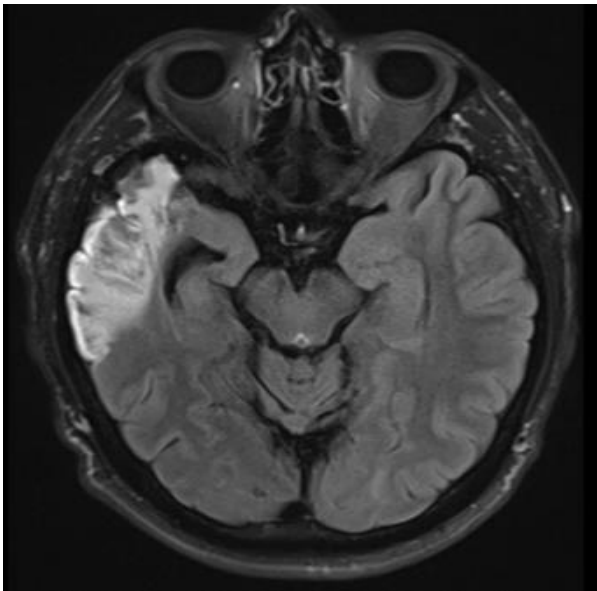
1 u 2-T1 images of the cerebrum–A zone of encephalomalacia in the right temporal and frontal region with a hemorrhagic transformation-1 (Original MRI performed at the clinic, reprinted with permission of the patient)
